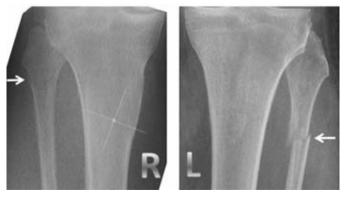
Pre-operative radiographs showing bilateral proximal fibular fractures; white arrows indicate the fracture lines.
